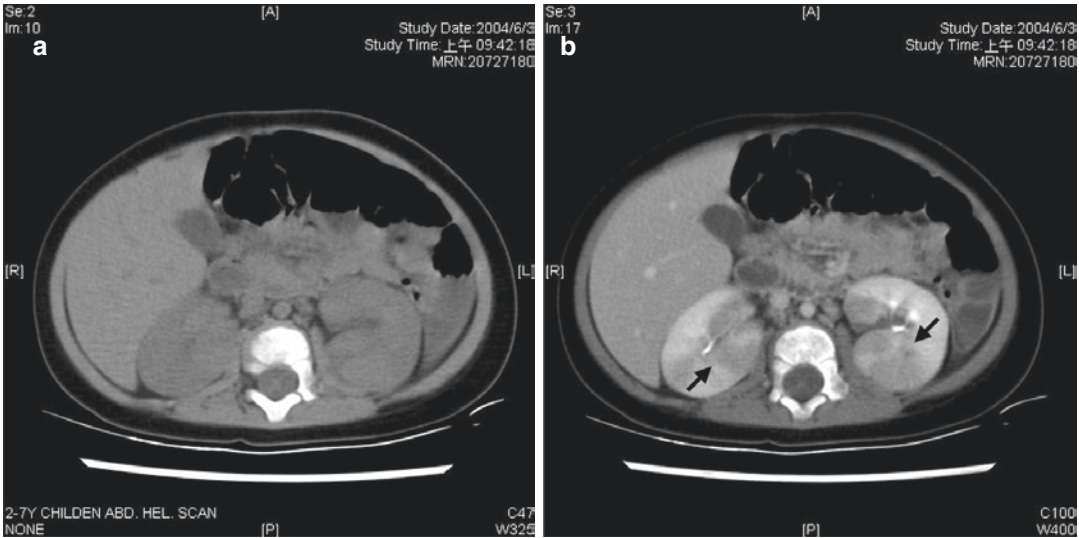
Characteristic pre-contrast (a) and contrast-enhanced (b) CT scans for an 8-month-old patient with acute lobar nephronia who presented with severe bilateral nephromegaly, but without a focal mass sonographically.
